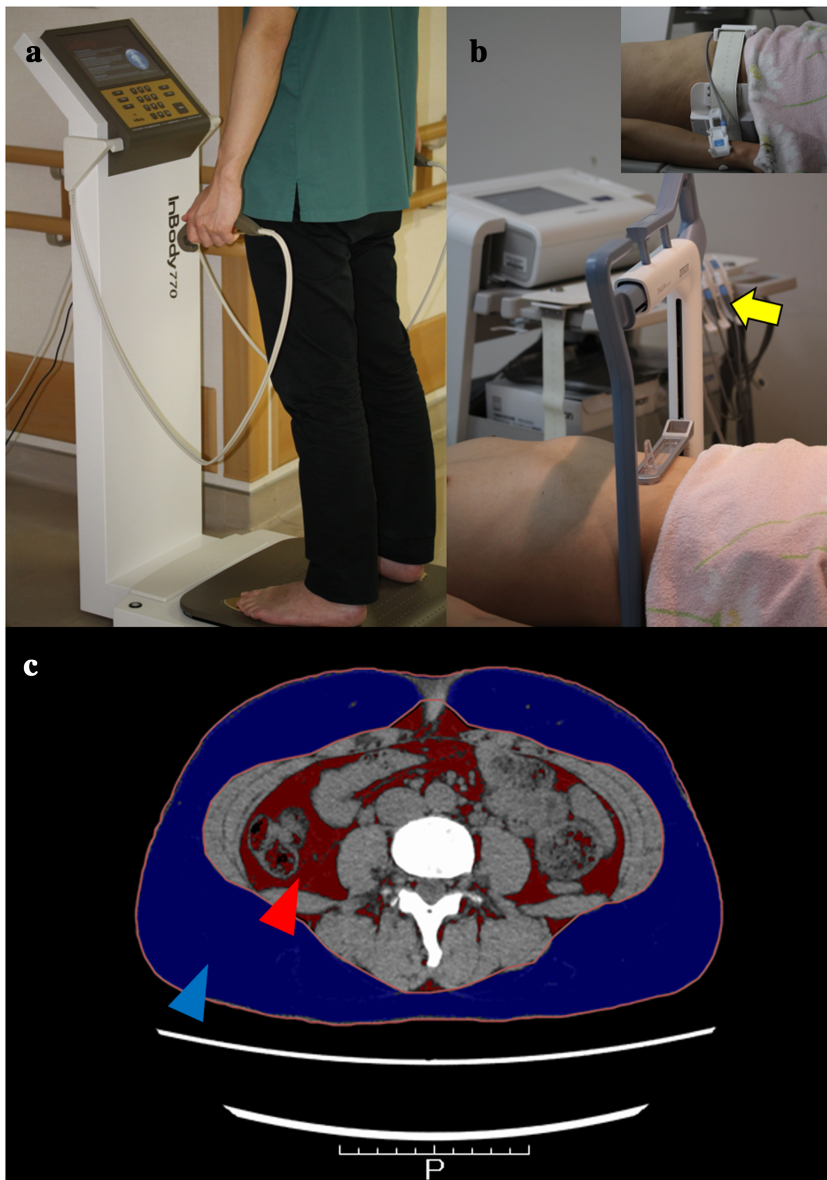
(a) Body composition and body water assessment using the InBody770 (TAKUMI Co., Aichi, Japan) and (b) visceral fat area and subcutaneous fat area evaluation using HDS-2000 DUALSCAN (FUKUDA Co., Tokyo, Japan). The yellow arrow indicates the abdomen measurement unit. (c) Computed tomography scan for the evaluation of visceral fat area (red solid area: red arrow) and subcutaneous fat area (blue solid area: blue arrow).
